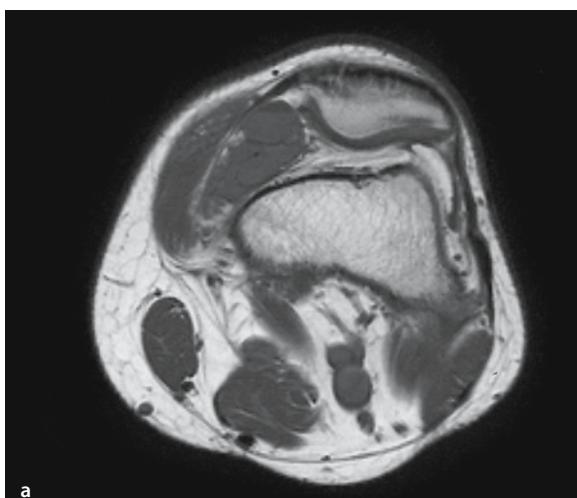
a Axial T1-weighted MR image. b Axial T1-weighted MR image after gadolinium contrast injection. c Sagittal T2-weighted MR image. A fluid–fluid level is seen on axial T1-weighted images. The supernate is slightly hypointense compared with the lower layer due to its serous composition (a). The fluid–fluid level becomes clearer after administration of gadolinium due to the sedimentation of gadolinium to the lower part of the lesion, the same phenomenon as is noted within the bladder after intravenous administration of gadolinium chelates (b). On T2-weighted images there is increased contrast between the hyperintense serous upper layer and the lower layer, which is hypointense due to the sedimentation of erythrocytes (c)
